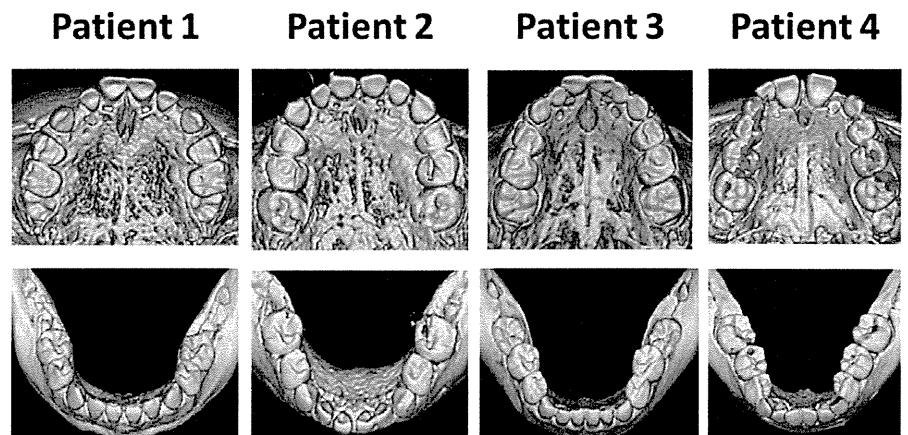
Multi-detector row computed tomography (MDCT)-synthesized upper and lower dental arches in all four patients. Small dental arches are noted in three patients (patients 2, 3 and 4). Patient 2 exhibited a U-shaped dental arch in the maxilla and narrow dental arch in the mandible; Patients 3 and 4 exhibited narrow dental arches in the maxilla and rectangle arches in the mandible.
